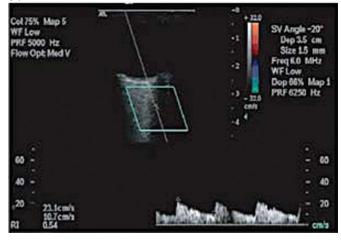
(a) Elevated optic nerve sheath diameter of 6.3 mm. (b) (A) Optic neuritis with significantly elevated peak systolic velocity and resistive index. (B) Contralateral normal eye of same patient with normal peak systolic velocity and resistive index. Adapted from Figure 1 of Hradílek P, Stourac P, Bar M, Zapletalová O, Školoudík D. Colour Doppler imaging evaluation of blood flow parameters in the ophthalmic artery in acute and chronic phases of optic neuritis in multiple sclerosis. *Acta Ophthalmol.* 2009;87(1):65–70. doi:10.1111/j.1755-3768.2008.01195.x.
